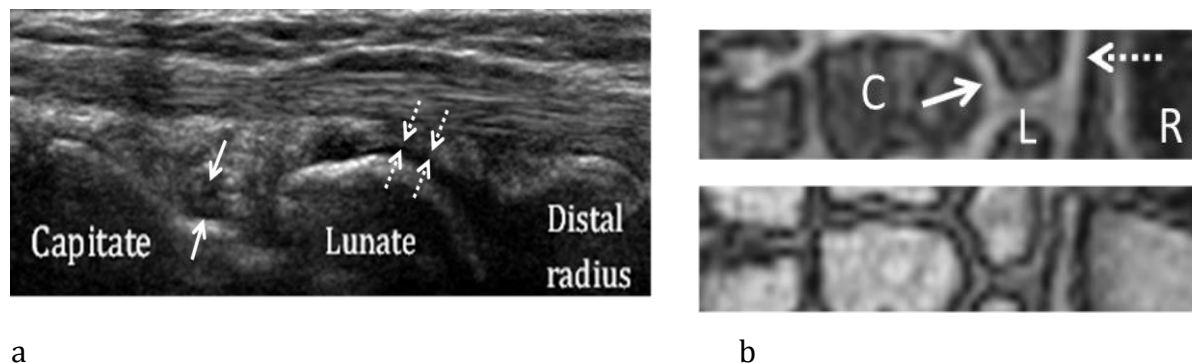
showing a) sagittal ultrasound image of the dorsal wrist and b) coronal MR-images (T1 weighted images before (bottom) and after intravenous contrast administration). Normal synovium in the midcarpal joints (arrows) and in the radiocarpal joints (stippled arrows). R=radius, L=lunate, C=capitate.
